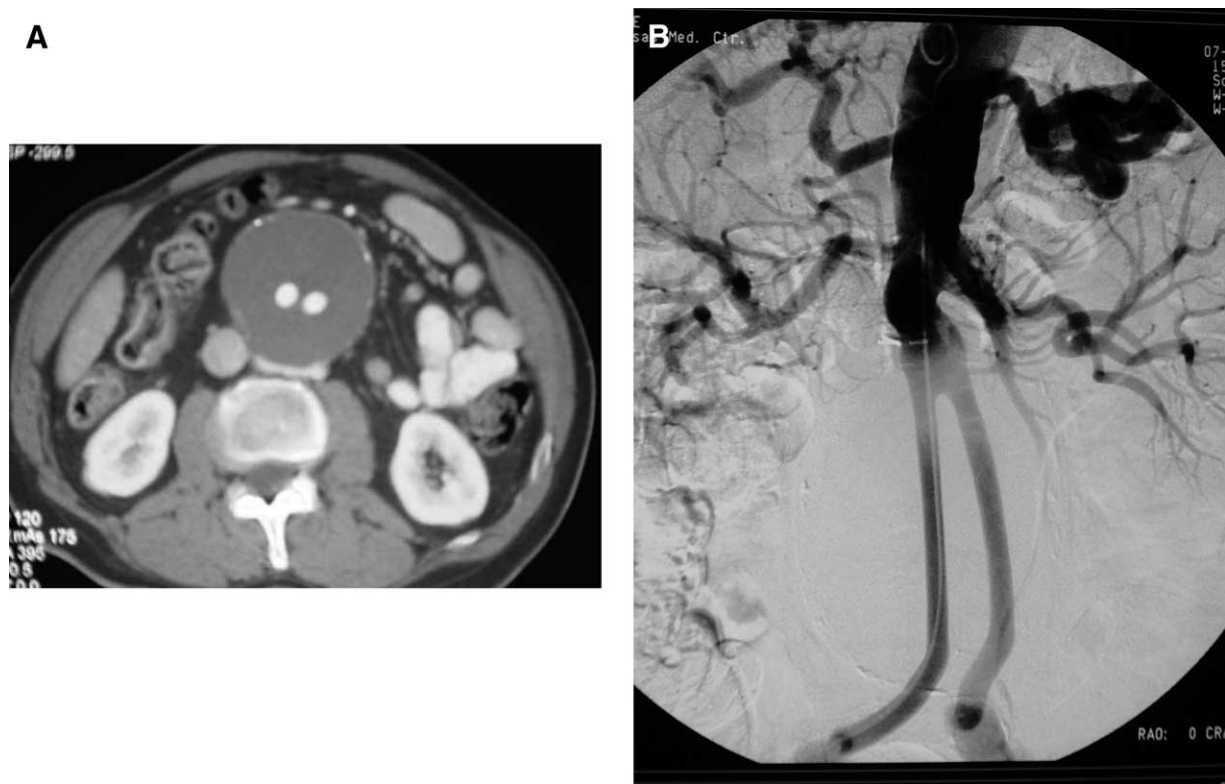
(A) Computed tomography scan demonstrates a perigraft seroma and distended aortic sac. (B) Digital subtraction angiogram shows an intact aortic graft without communication with the perigraft seroma.
